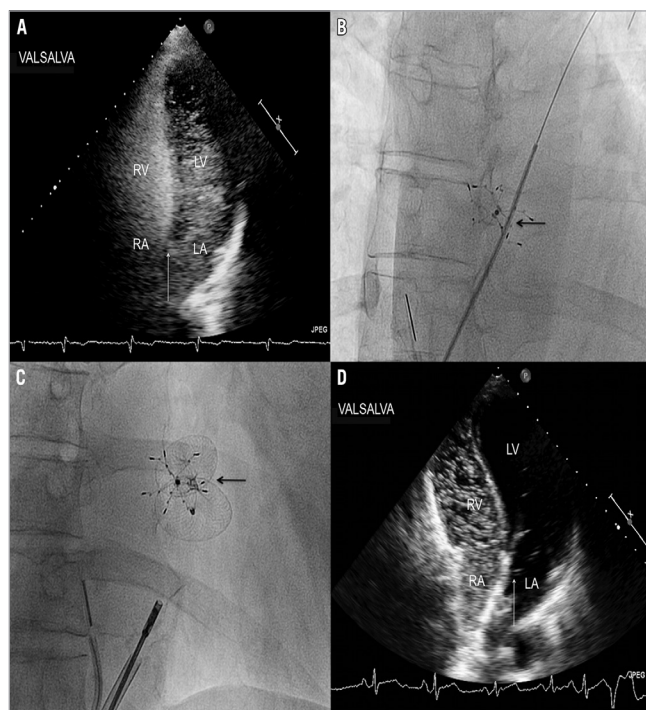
A) Contrast transthoracic echocardiogram (TTE) at three-year follow-up. During Valsalva a severe right-to-left shunt is visible (arrow). B) Fluoroscopic view of the bioabsorbable device (arrow) with the catheter passed through the residual opening. C) Fluoroscopic view of the bioabsorbable device and the Occlutech Figulla device (arrow). D) Contrast TTE 1 day after intervention. During Valsalva a small right-to-left shunt is visible (arrow).
